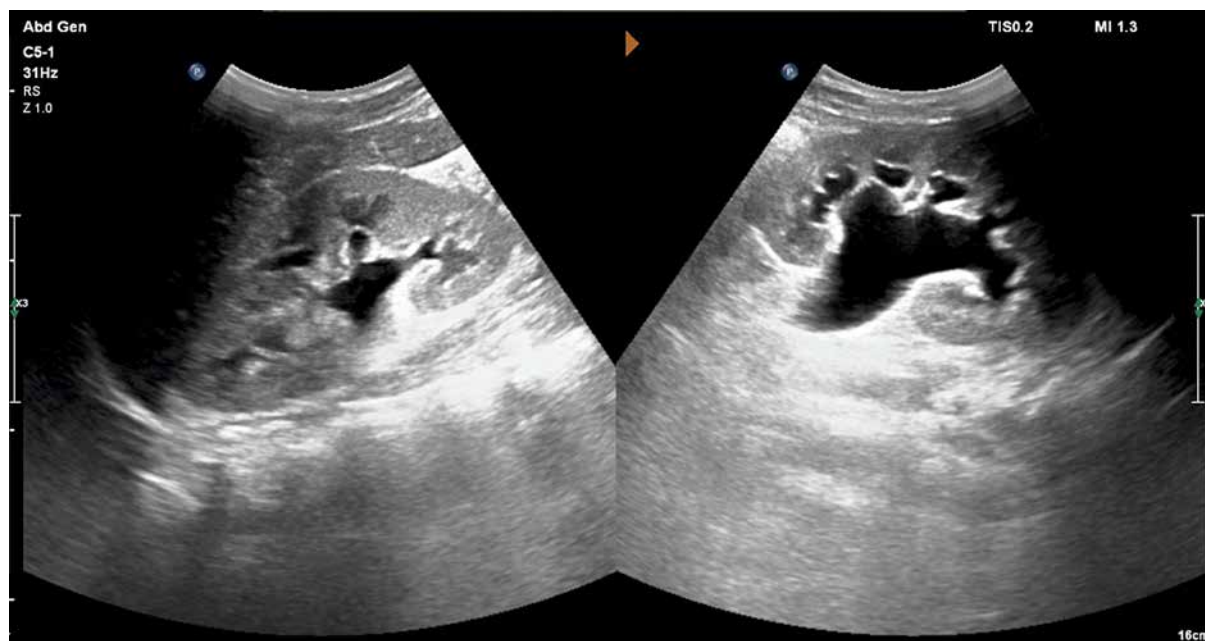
Ultrasound showing left hydronephrosis
